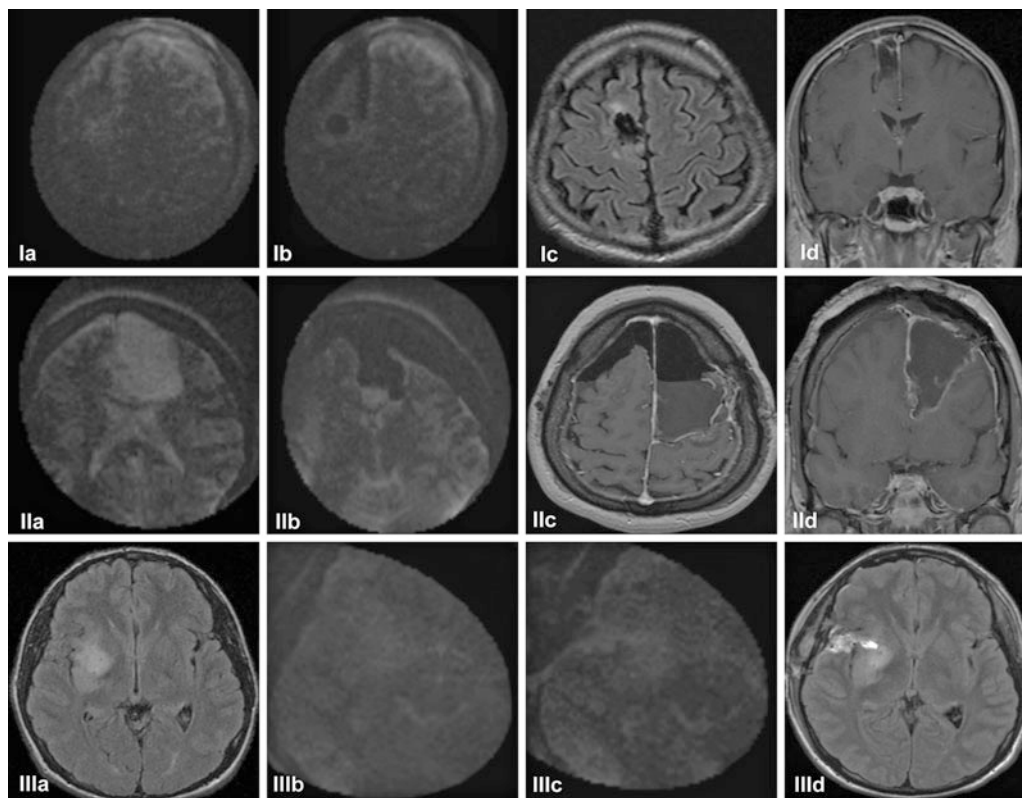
Upper row: T2-weighted ioMR imaging obtained prior to tumor resection shows hyperintense signal in the right frontal lobe (Ia). Repeated scan after resection shows surgical cavity and removal of lesion (Ib), as confirmed by postoperative MRI, respectively axial FLAIR (Ic) and coronal T1-weighted with contrast (Id). Middle row: pre-resection ioMRI shows a large left frontal lesion hyperintense in T2-weighted sequences (IIa). Follow-up intraoperative scan shows residual tumor as a hyperintense area in the posteromedial part of the surgical cavity (IIb) which was thereafter addressed. Postoperative axial (IIc) and coronal (IIId) T1-weighted images with contrast show gross total tumor resection. Lower row: Preoperative MRI is significant for a large left frontotemporal lesion (IIIa) with areas of contrast enhancement (IIIb). Postoperative imaging shows large surgical cavity without evidence of residual tumor (IIIc–IIIId). In this case ioMRI was not obtained because of technical difficulties
